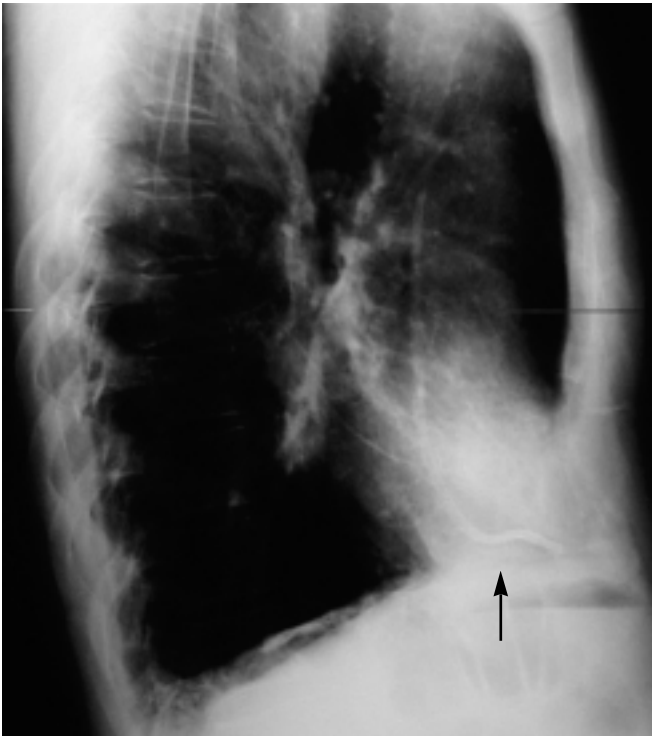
Chest-X-ray showing an embolized catheter; the end of the fragment is located in the right ventricle.
